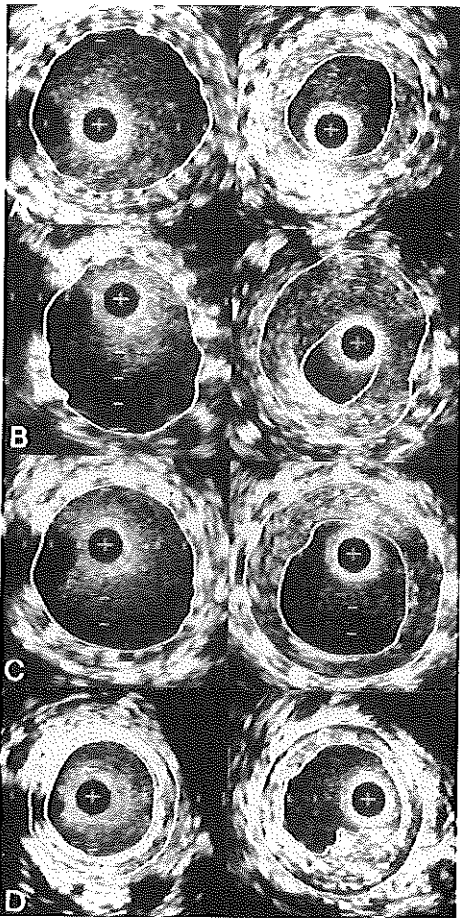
Matched intravascular ultrasound cross-sections of the superficial femoral artery obtained immediately after stent deployment (*left panels*) and at 11 months follow-up (*right panels*). The lumen area (inner contour) and stent area (outer contour) are responsible for the quantitative results. A, Some intimal hyperplasia is seen in the stent. B, Intimal hyperplasia is the dominant mechanism responsible for restenosis seen at the stent junction. Besides, stent area enlarged. C, At the stent edge, intimal hyperplasia and stent area enlargement are seen. D, At the reference segment, vessel area enlargement is evident. + = catheter; calibration = 1 mm.
